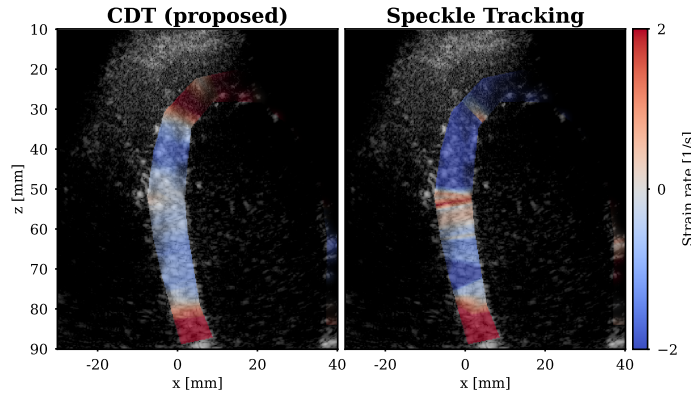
Strain rate maps recovered from a diverging wave acquisition of a healthy volunteer (apical 4-chamber view). The myocardium was manually delineated and the strain rate maps were computed and are shown in the myocardium.
